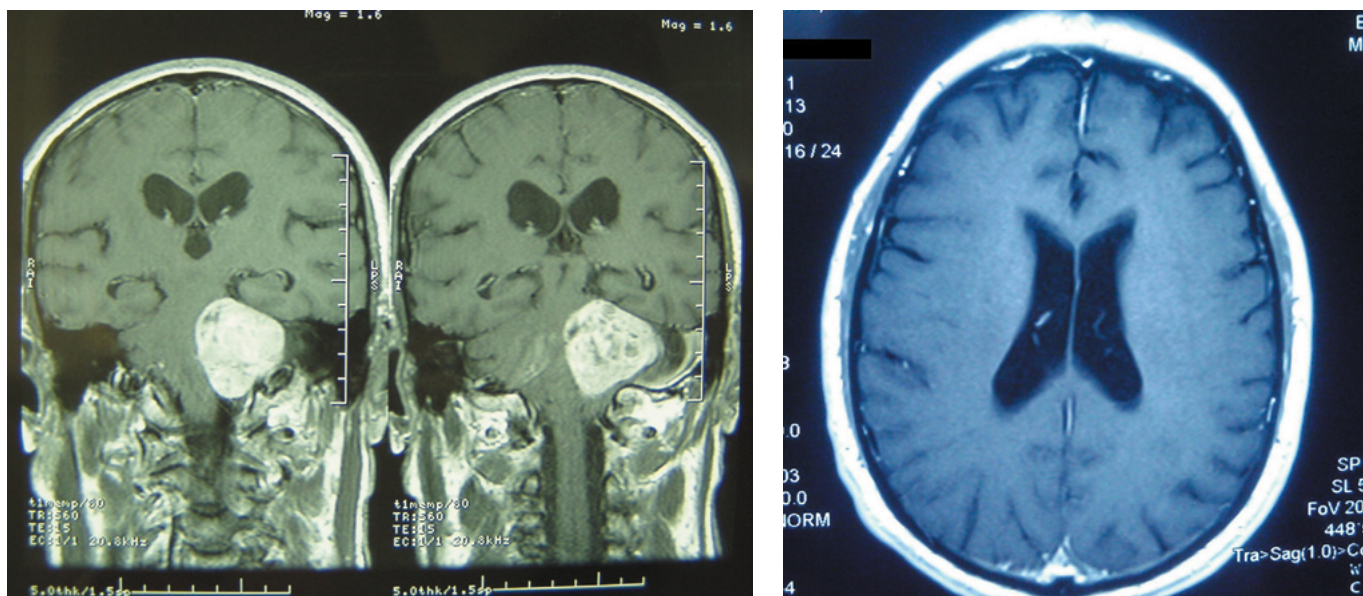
Preoperative brain MRI of the patient revealed a left cerebellopontine angle tumor with intense inhomogeneous accumulation of paramagnetic contrast agent. Lateral ventricles are dilated. Preoperative coronal and axial contrast-enhanced T1-weighted MR images.
